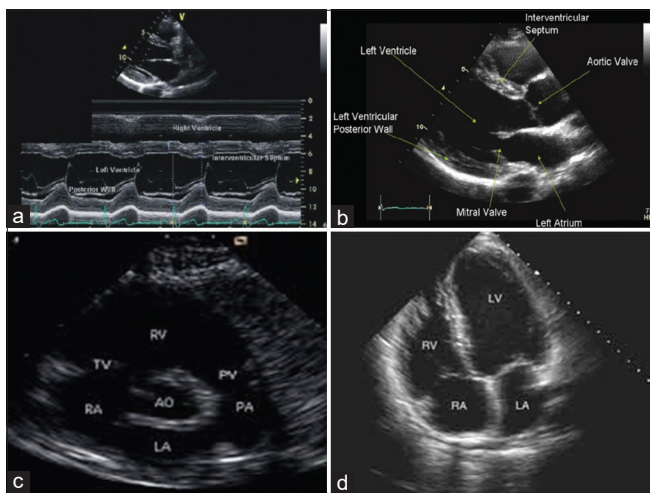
Echocardiographic windows of cardiac structures and function: (a) Upper left quadrant = M-mode showing ventricular function and dimension, (b) Upper right quadrant = Parasternal long-axis view, (c) Lower left quadrant = Parasternal short-axis view, (d) Lower right quadrant = Four-chamber apical view
